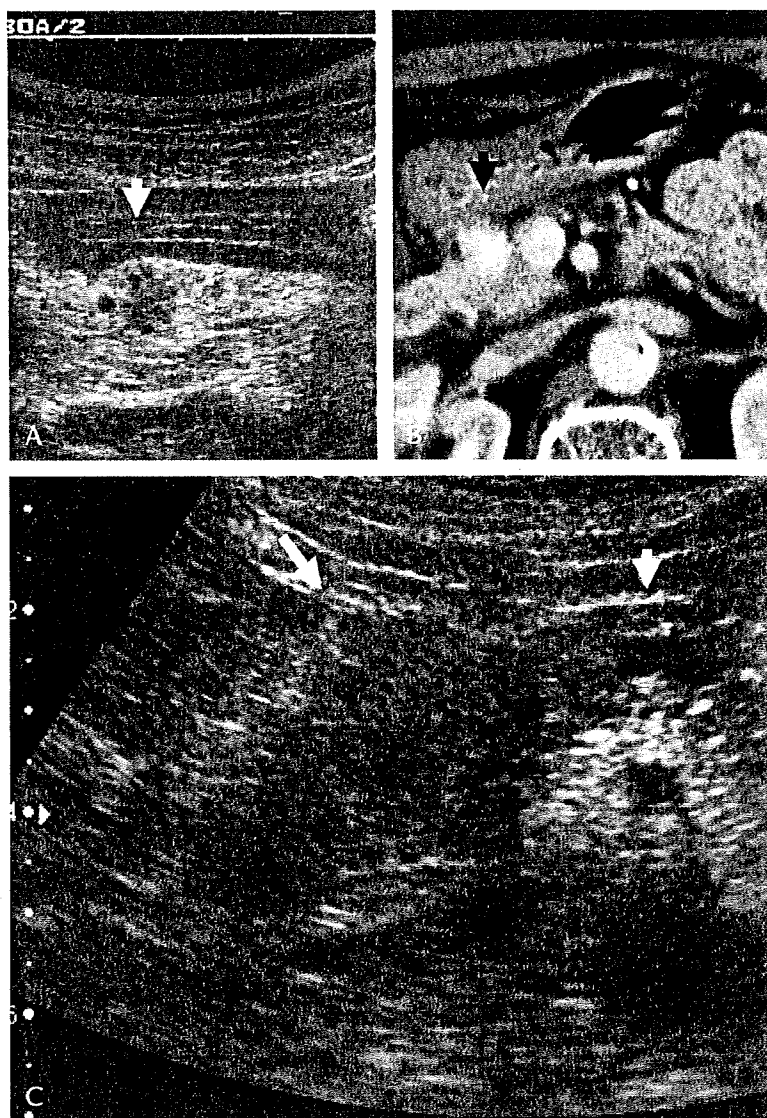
A, The US shows a small low-echoic mass measuring 12 mm in size. The white arrow indicates a small tumor. B, Enhanced CT in the late phase shows a round hyperattenuating lesion in the pancreatic head. The black arrow indicates a small tumor. C, The US shows a low-echoic mass 30 mm in diameter, with dilation of the main pancreatic duct. The white arrow indicates a tumor, and the black one the dilated main pancreatic duct.
